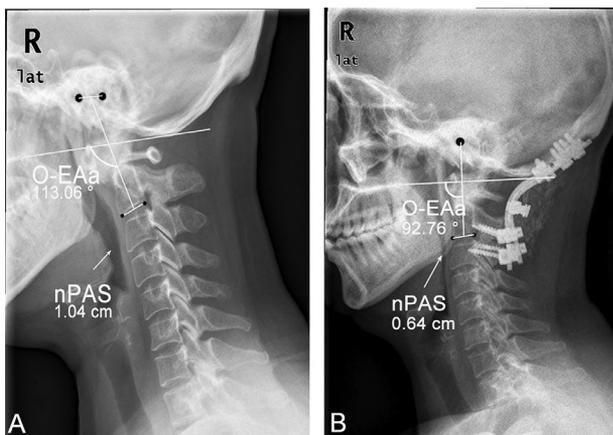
A case of postoperative dysphagia. (A) The preoperative values of O-EAa and O-C2a were 113.06° and 20.47°, and nPAS was 1.04 cm. (B) The patient suffered from obvious dysphagia after surgery. Postoperative X-rays after surgery showed that O-EAa and O-C2a were 92.76° and 6.64°, respectively. The oropharyngeal space developed obvious stenosis, and nPAS decreased to 0.64 cm. O-EAa, O-EA angle; O-C2a, O-C2 angle; nPAS, the narrowest oropharyngeal airway space.
